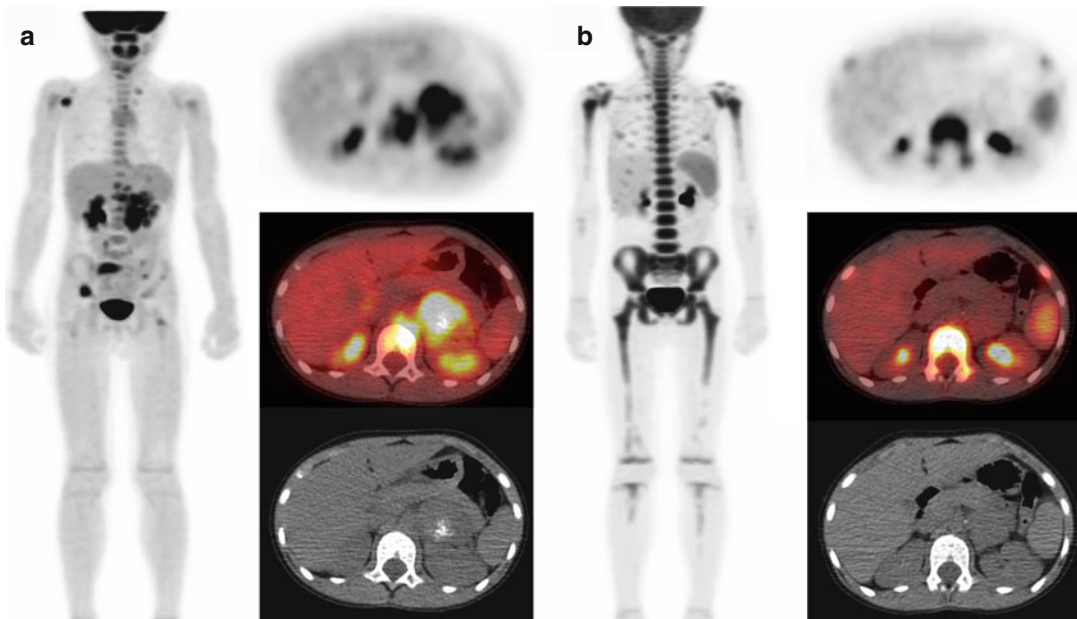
Serial ^{18}F -FDG anterior projection MIP and axial PET/CT images in a patient with stage 4 neuroblastoma. (a) At diagnosis, ^{18}F -FDG uptake is seen in the primary partially calcified left retroperitoneal tumor, retroperitoneal lymphadenopathy, and multiple skeletal metastases (most notably involving the right glenoid, L1 vertebral body, right sacrum, and right iliac bone). (b) After chemotherapy and G-CSF therapy, intense diffuse
